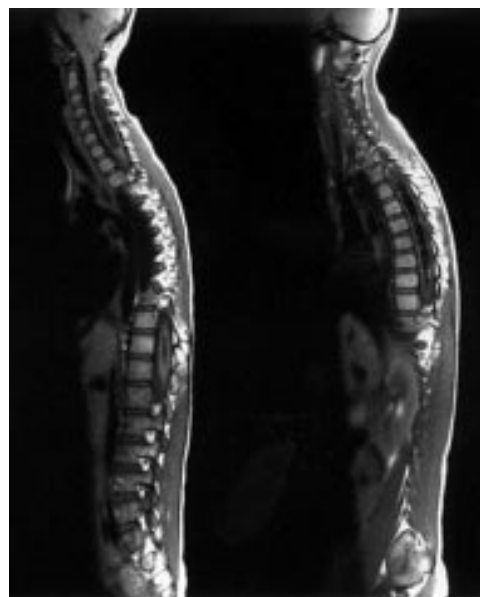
Selected sagittal T1 weighted magnetic resonance images of the whole spine in a girl with a minor scoliosis and asymmetrical abdominal reflexes showing a syrinx of most of the cord and cerebellar tonsillar herniation, consistent with a Chiari 1 malformation.
